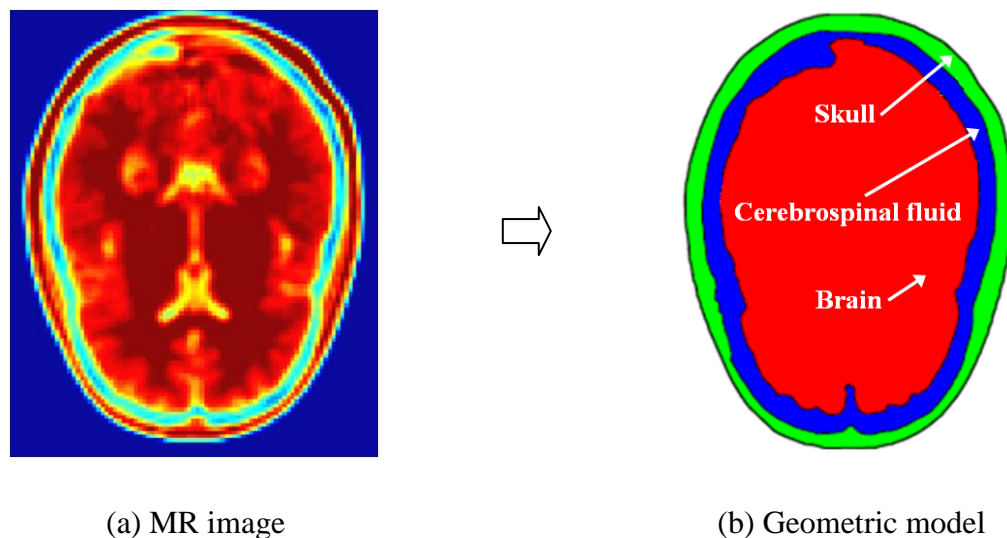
Constructing a geometric model from a MR image
